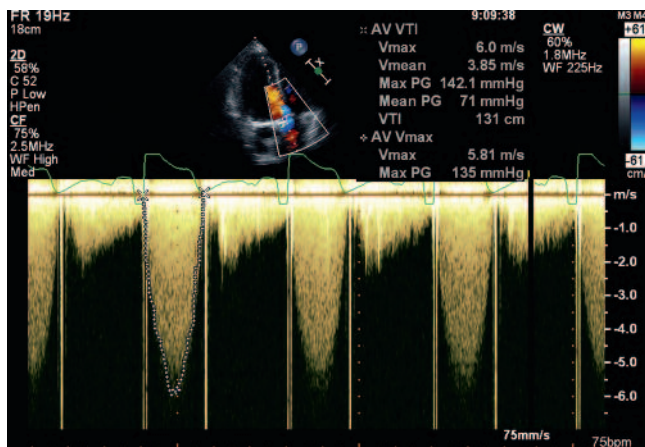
Continuous wave Doppler signal showing aortic V_{\max} of 3.9 m/s and mean gradient of 71 mmHg.
